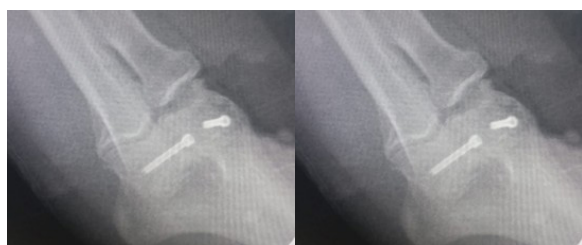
Anteroposterior radiograph of the screws
